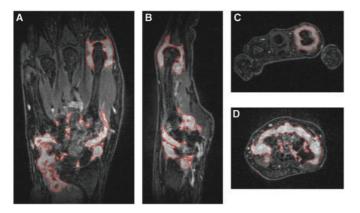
Coronal (A), sagittal (B) and axial (C, D) sections through a 3D T1-weighted fat-suppressed image of the wrist and MCP joints. The volume of enhancing synovium has been manually outlined. Images acquired using 3D fat-suppressed VIBE sequence at 3T (TR=8 ms, TE=4 ms, flip-angle=30°, 0.5 mm isotropic resolution).
